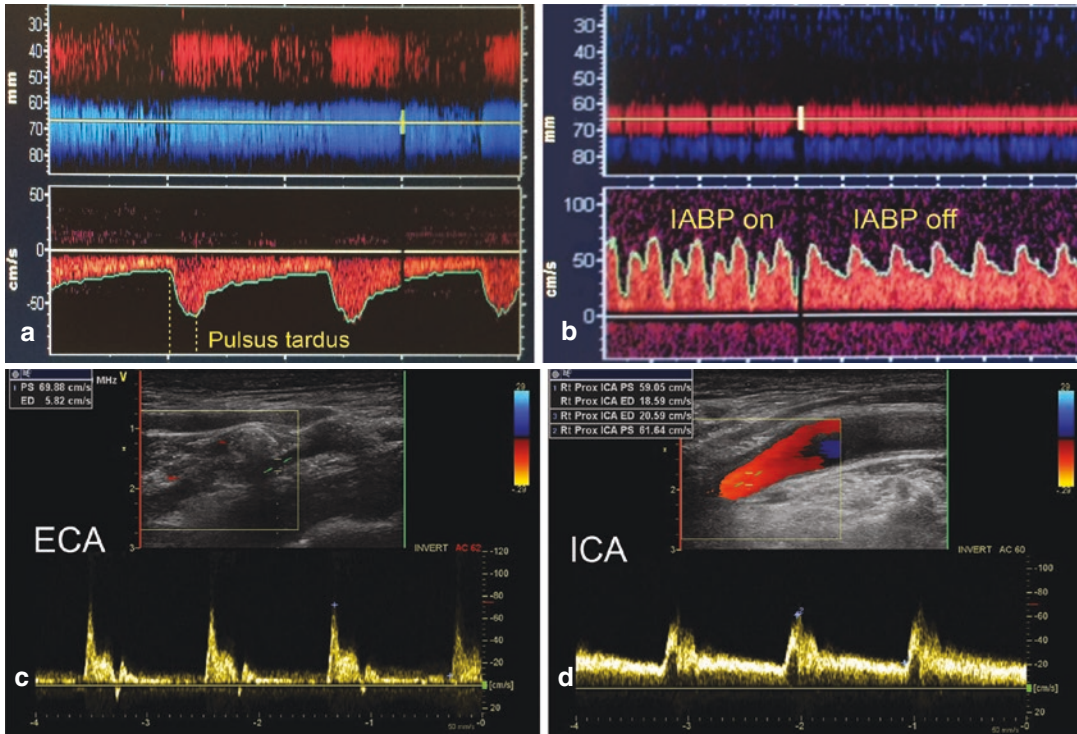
Examples of factors affecting the arterial pressure waveform. (a) Delayed systolic upstroke observed on transcranial Doppler in a patient with severe aortic stenosis. (b) Modification of the transcranial Doppler waveform in a patient with an intra-aortic counterpulsation balloon pump (IABP). (c) Doppler waveform of the external carotid artery (ECA) compared with the (d) internal
